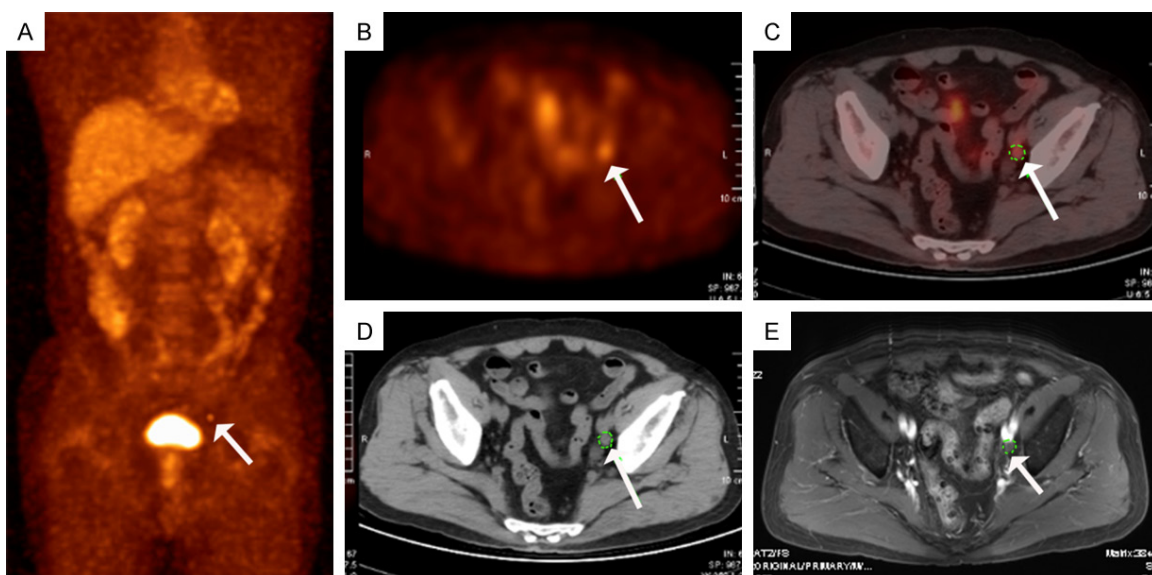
In a 75-year old prostate cancer patient with Gleason sum of 9 (5+4), FDG PET/CT identified a metastatic lymph node of left lateral iliac artery with SUVmax of 4.0, showing high FDG uptake (A-D) while it was diagnosed as negative report based on the criteria of DWI-MRI, which was only 0.7 cm in diameter without hyperenhancing (E).
